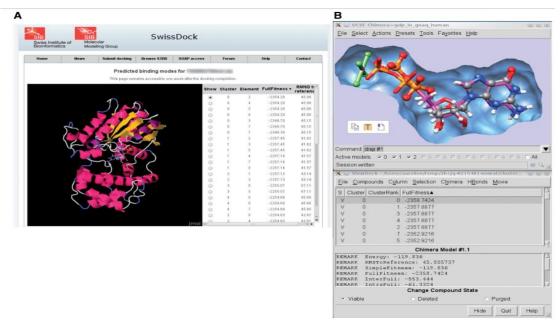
This figure shows a typical output of SwissDock for the docking of the Guanine nucleotide-binding protein G(q) subunit alpha, a target involved in uveal melanoma (35). (A) Screenshot of the Jmol applet which renders predicted BMs within the web browser. (B) Visual investigation using the ViewDock plugin of UCSF Chimera. The predicted BM of the guanosine diphosphate (magenta sticks) is superimposed to the X-ray BM (ball and sticks). As it can be seen in the lower part of the figure, this particular predicted BM has the most favorable energy[43]
